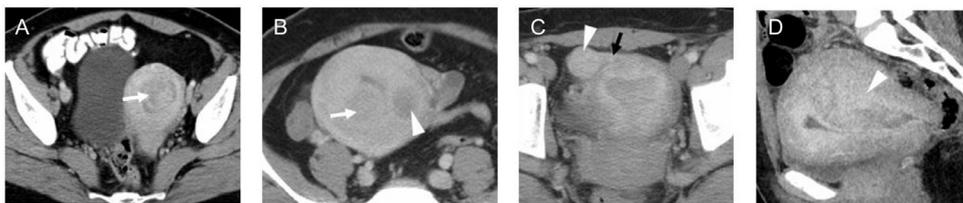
Fibroids are the most common neoplasm of the uterus, with varying appearances. (A) and (B) axial CT images of different patients with a submucosal fibroid (white arrows). (B) also shows a cystic intramural fibroid (arrowhead). (C) axial CT image shows a pedunculated subserosal fibroid (arrowhead) with a well-defined stalk (black arrow) which is at risk for torsion. (D) sagittal CT image with large heterogeneous intramural fibroid (arrowhead) deforming the endometrium.
